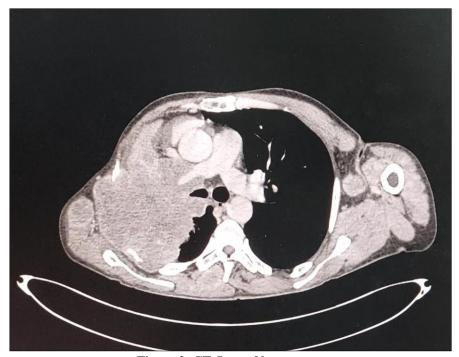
CT-Scan of lung tumor
